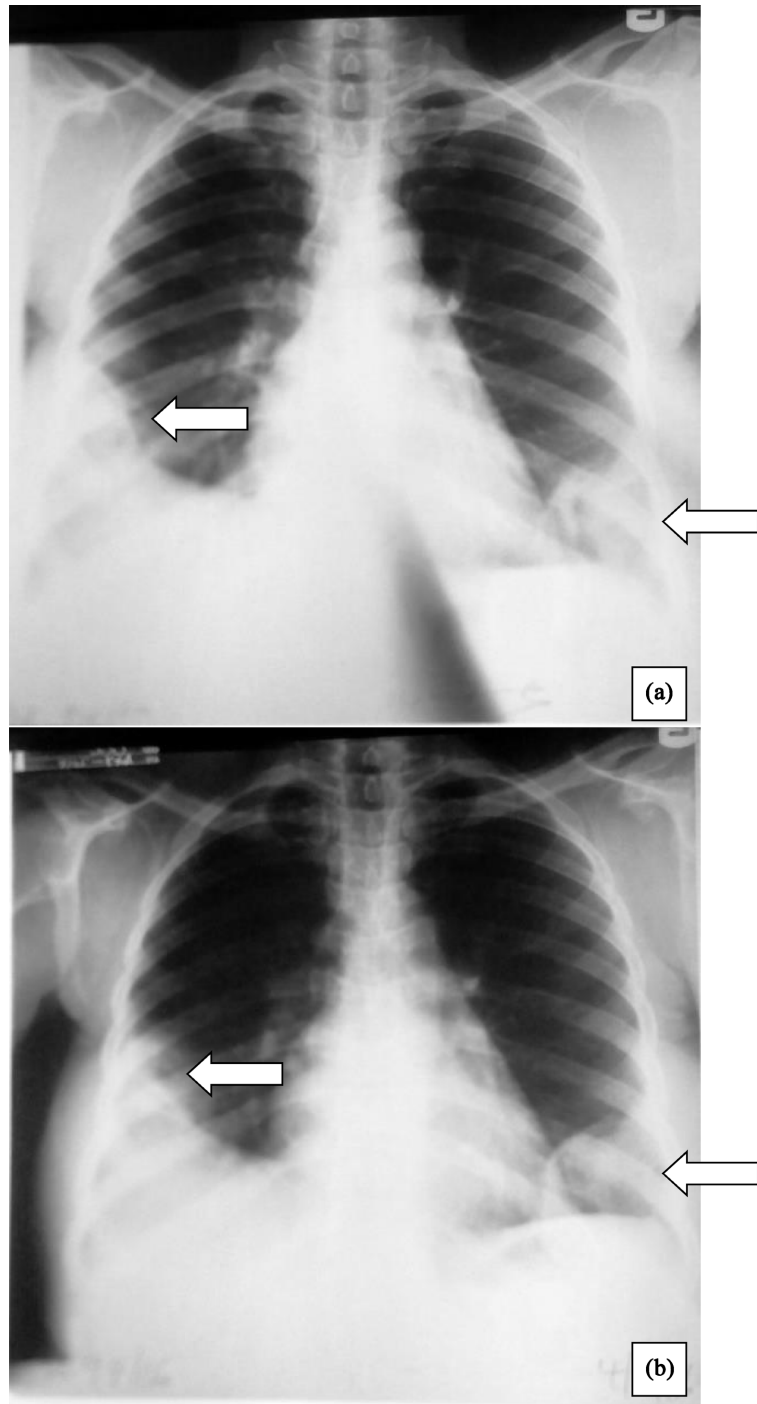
(a) PA Chest X-ray done at presentation showing pleural based opacities with mottled lucencies (arrows) in both lower lung zones with associated silhouetting of the right hemidiaphragm. Repeat radiograph a week later (b) shows minimal resolution with evidence of cavitation of the lesions.
